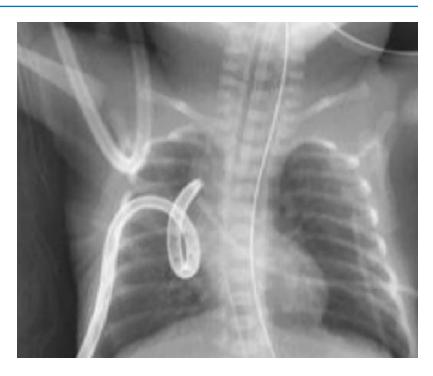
Chest radiograph showing a spontaneous right-sided tension pneumothorax
